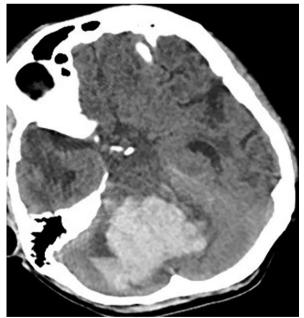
Brain CT showing large cerebellar hemorrhage.
